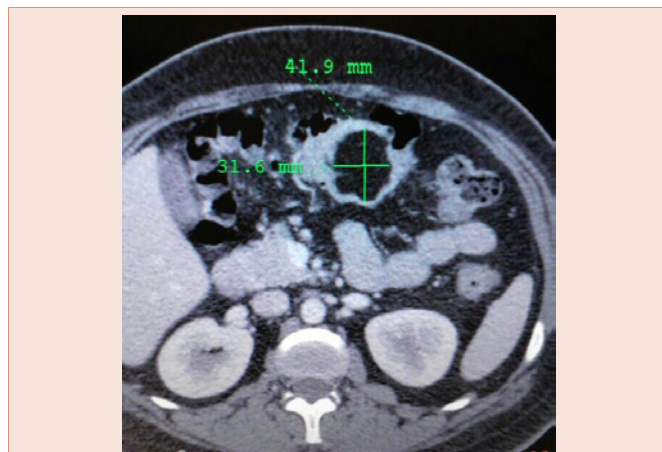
CT scan showing lipoma that measures 1.57x1.18 inches.
